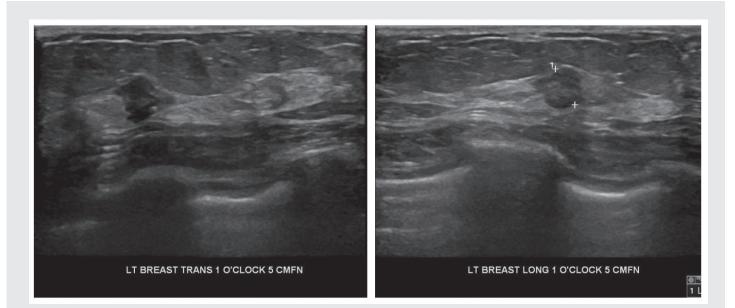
Figure POP3. L breast ultrasound images. Presence of marker resulted in quicker and easier location of mass and allowed ultrasound guided biopsy rather than stereotactic biopsy to be performed.
